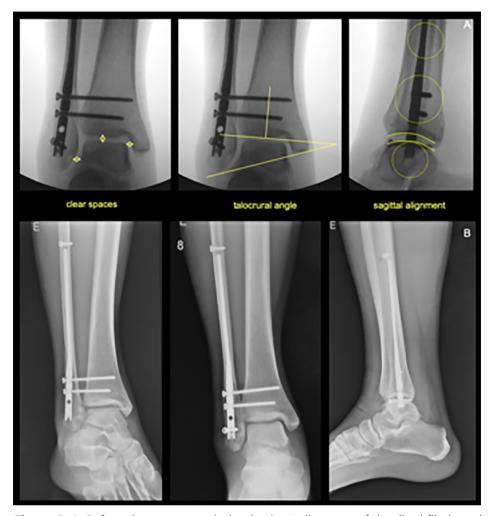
A, Before closure, anatomical reduction / alignment of the distal fibula and correct position and size of the locking screws are checked with the C-arm. In addition, syndesmosis reduction and tibiotalar joint congruency are confirmed using the existing radiographic parameters. B, Final X-rays are done before patient leaves the OR.
